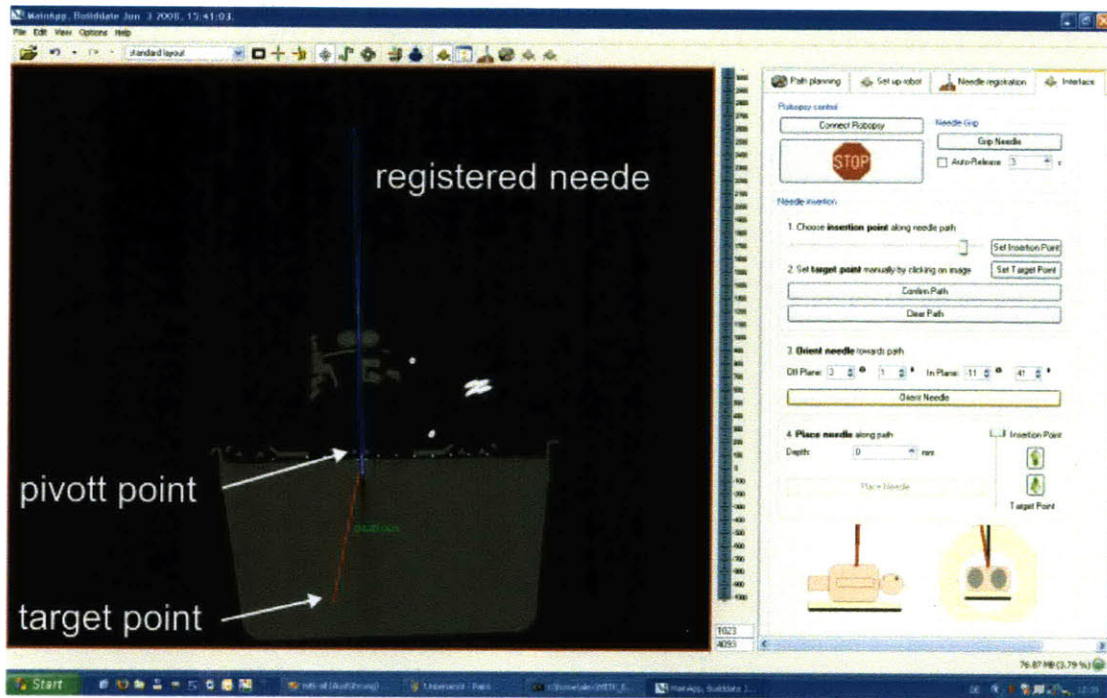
The interface incorporates images, aids planning and enables point-and-shoot lesion targeting. The user defines a path and needle in across multiple CT slides in 3D by clicking on points on the 2D medical images.
